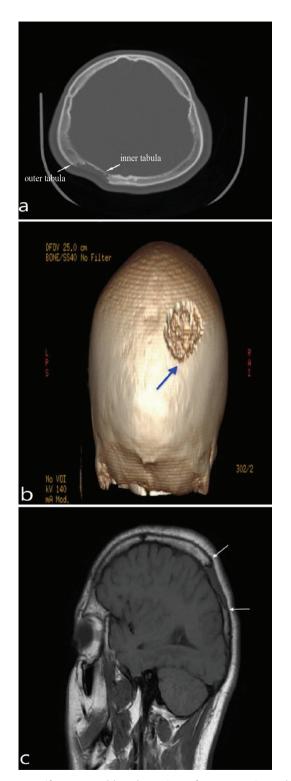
Fifteen-year-old male patient: from a section taken at the a-transverse computed tomography (CT) bone window, a lytic lesion of about 4 cm in diameter destructing the outer tabula in the right parietal bone posterior was found (a); The inner tabula was kept 3D CT inspection (b); Sagittal T1-weighted magnetic resonance imaging shows no intracranial extension of the destructive lytic lesion (between the arrows) (c)
